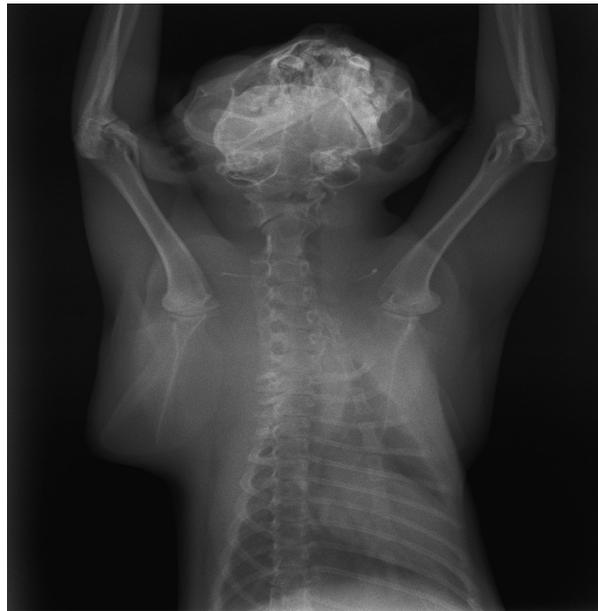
The radiographic image of left scapular luxation.
